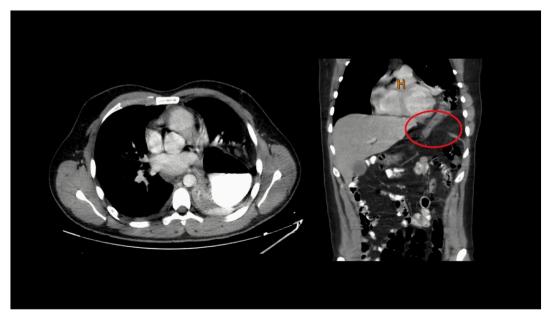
CT-scan showing herniation of the stomach in the left hemithorax.
